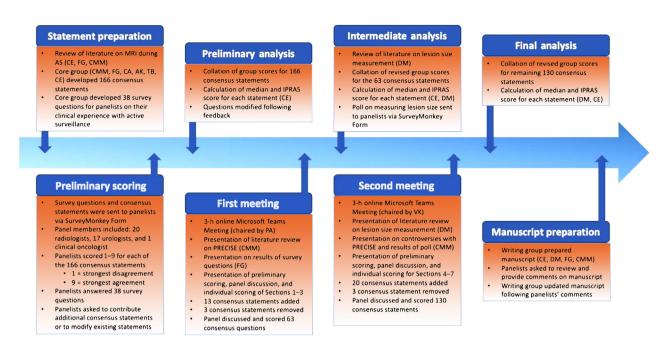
The PRECISE v2 consensus meeting process. AS = active surveillance; IPRAS = Interpercentile Range Adjusted for Symmetry; MRI = magnetic resonance imaging; PRECISE = Prostate Cancer Radiological Estimation of Change in Sequential Evaluation.
